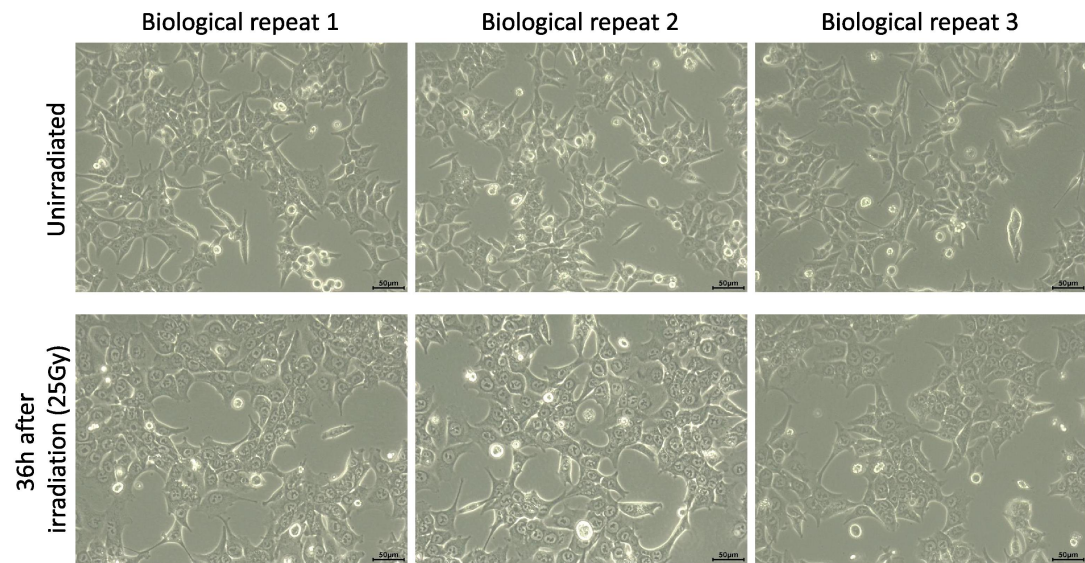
Tumor cells swell substantially after clinical-dose X-ray irradiation. Upper: unirradiated HCT116 cells; Lower: HCT116 cells 36 hours after 25Gy irradiation
